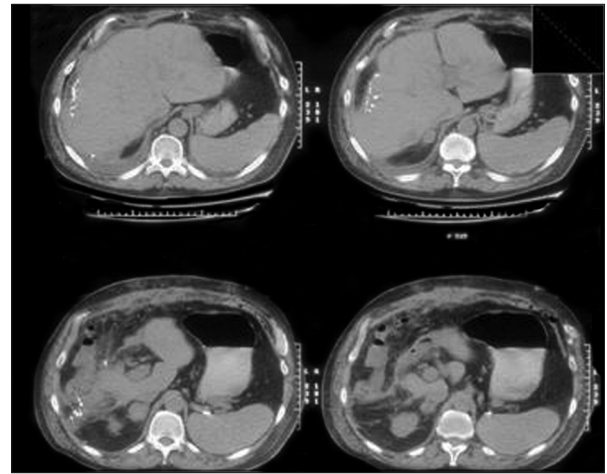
CT abdomen, revealing large solitary liver lesion
